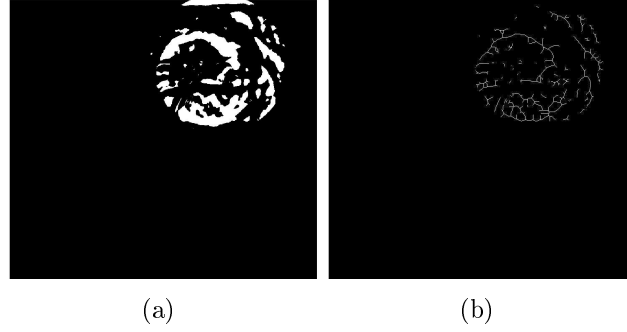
(a) Pixels in \mathcal{B}_m . These pixels are close to the X-ray marker and point to the X-ray marker. (b) The and associated skeleton.
